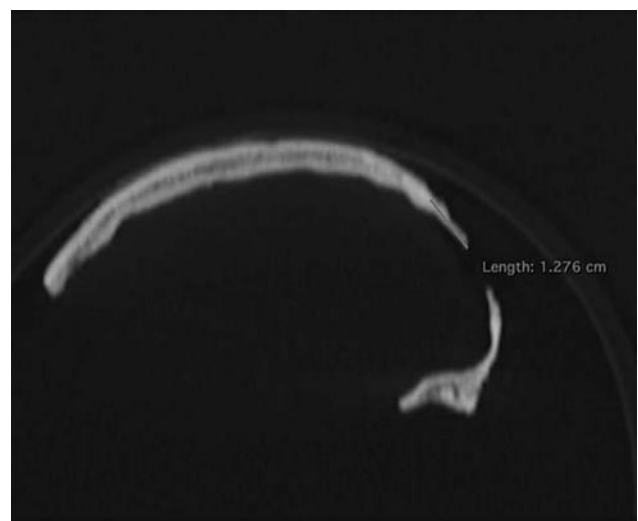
Multiplanar reconstruction (MPR), sagittal plane, CT scan, Jagodnjak (scan by M. Čavka).
